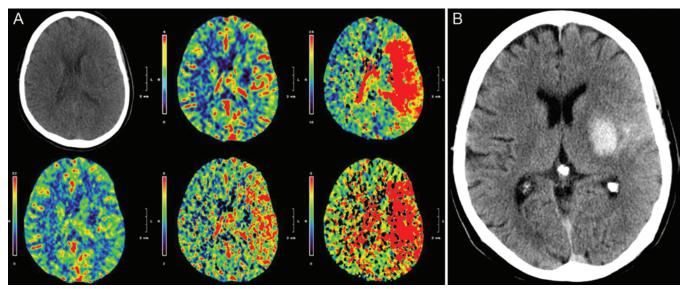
A: Noncontrast CT scan and perfusion maps obtained in a patient with a left M₂ superior trunk occlusion (NIHSS score 12), showing a large area of increased MTT and time-to-peak penumbra, indicating potentially salvageable brain (*upper middle* and *bottom middle*, respectively). However, the perfusion mapping shows significant signal loss in the left basal ganglia (*upper middle*). B: Noncontrast CT scan obtained following mechanical thrombectomy and angioplasty, showing a parenchymal hematoma in the left basal ganglia.
